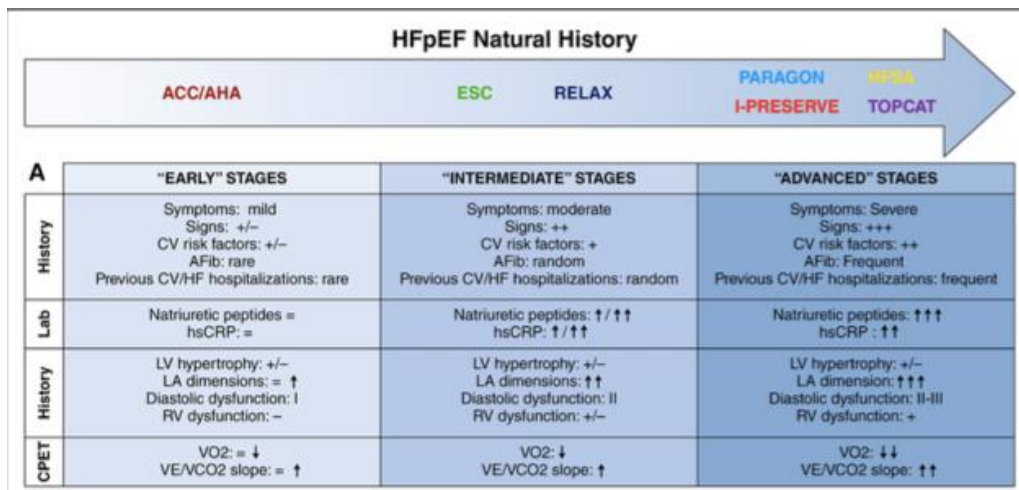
Successive stages of disease severity that can be described on clinical basis according to a noninvasive multiparametric assessment including clinical history, blood tests, echocardiography, and cardiopulmonary exercise test [5].
